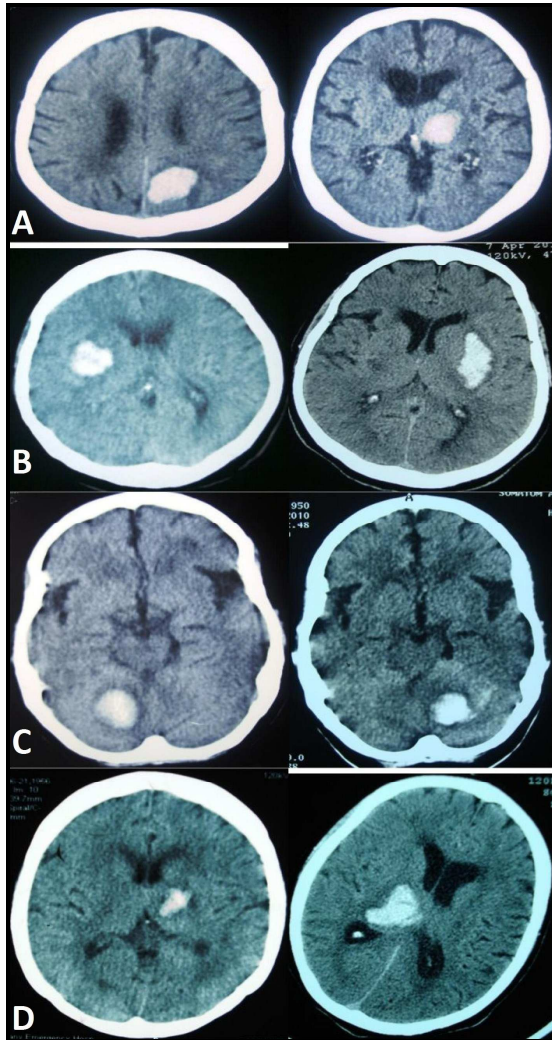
Non-contrast CT brain scanning of patients 1(A), 2(B), 3(C), and 4(D) respectively. All of these scans were done at the time of Acute&Emergency department visit. The scans on the left side represent the first hemorrhagic stroke while the right slices are the recurrent ones. Note that in patients 2, 3, and 4 the hemorrhages had recurred on the contralateral anatomical counterpart area.
